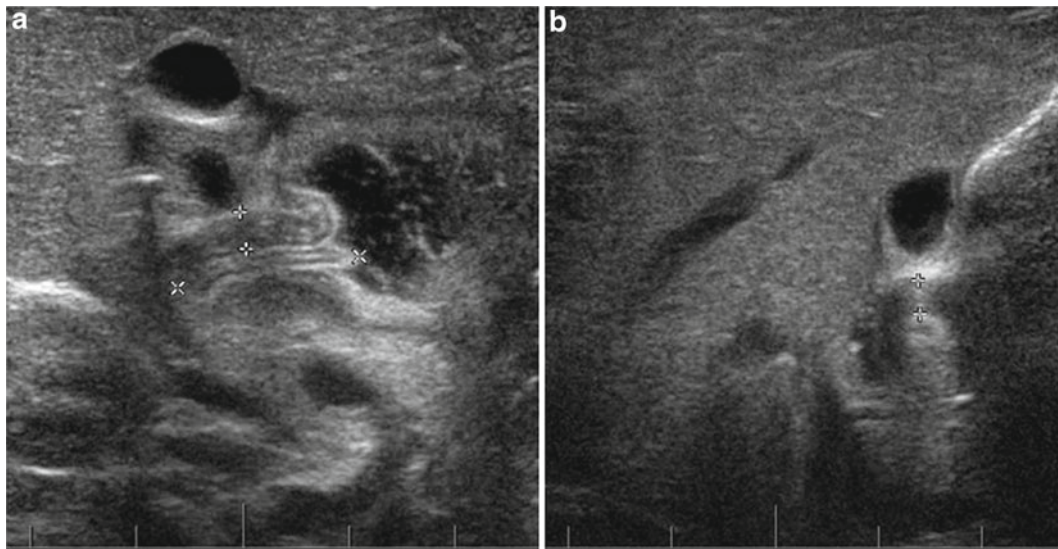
Ultrasound images of a 3-week-old infant with HPS. (a) A longitudinal view with a pyloric length of 18 mm and a pyloric muscle thickness of 3.9 mm. (b) Transverse view demonstrating the pyloric muscle thickness
